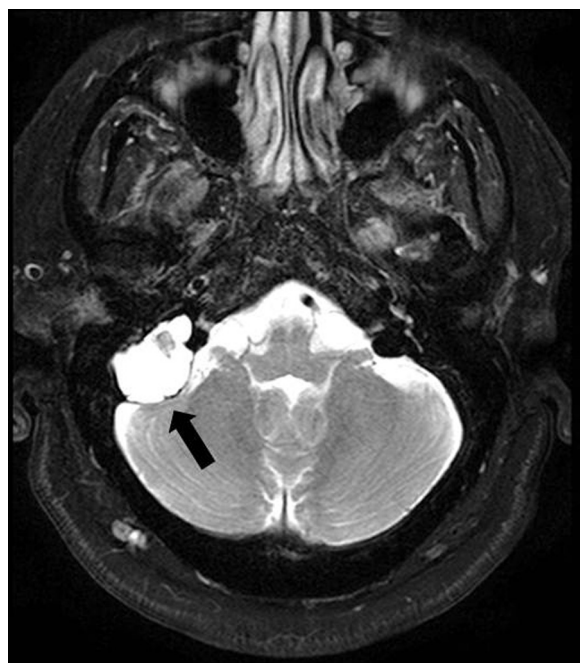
T2-weighted postgadolinium magnetic resonance imaging scan showing a well-circumscribed lesion present in the right cerebellopontine angle with heterogeneous enhancing signal with the exception of a central hypointense nodule (arrow).
